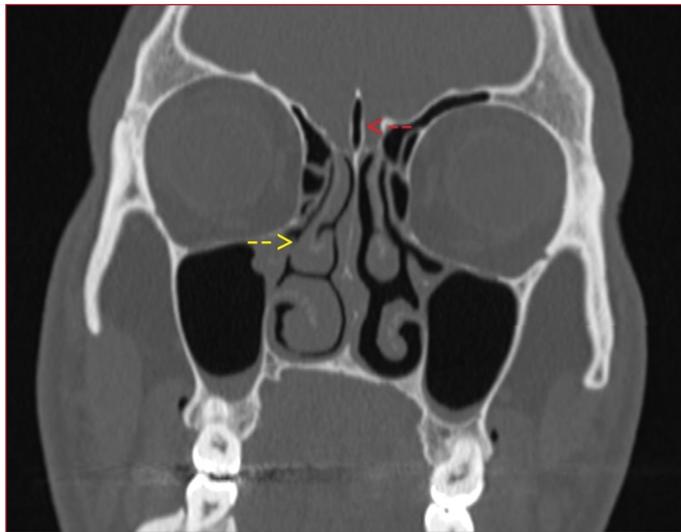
Anatomical variations in the coronal plane CT image. yellow arrow: paradoxical middle turbinate. red arrow: pneumatized crista galli.
